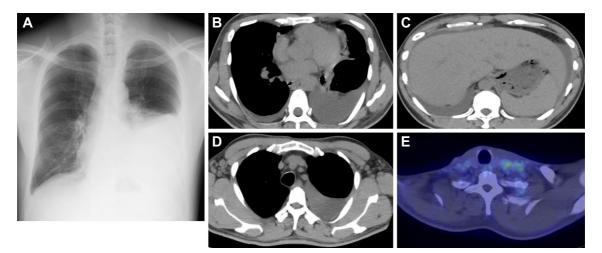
Chest radiography, CT, and FDG-PET images on admission. (A) The chest radiograph showed a left pleural effusion. (B, D) Chest CT revealed bilateral pleural effusion and the enlargement of the axillary lymph nodes. (C) Abdominal CT revealed ascites and hepatomegaly. (E) The FDG-PET images showed a mild FDG uptake in the left supraclavicular lymph nodes (maximum standardized uptake value 3.1).
